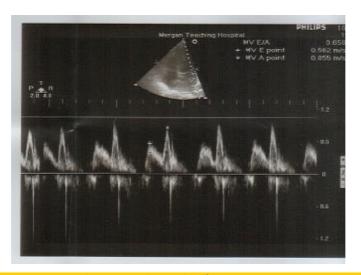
Echocardiograph taken from a patient with CML show that the E velocity is 0.562 and A velocity is 0.855 and E/A ratio = 0.657 (i.e < 1)
